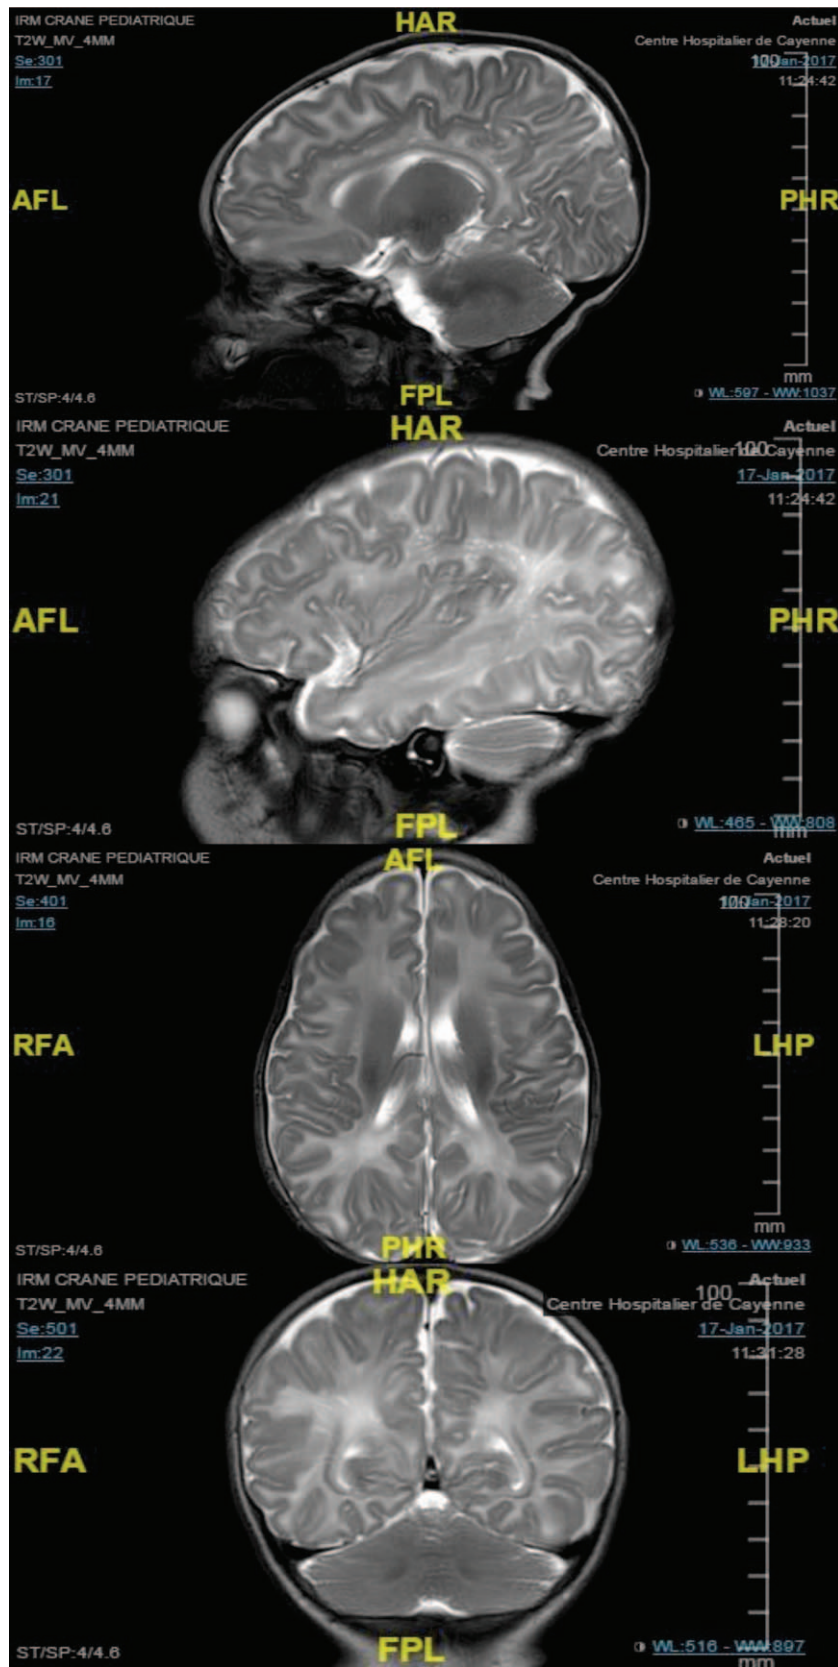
Patient number 1: Cerebral MRI showing diffuse white matter hyperintensity. T2 sequence. MRI=magnetic resonance imaging.
